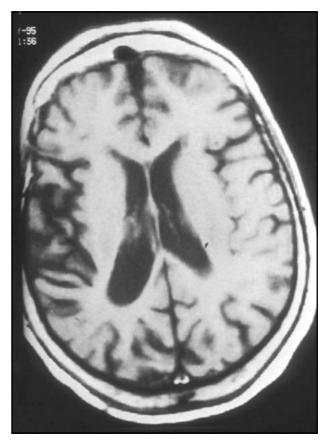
(patient 1). Right temporo-parietal atrophy disclosed by MRI.
